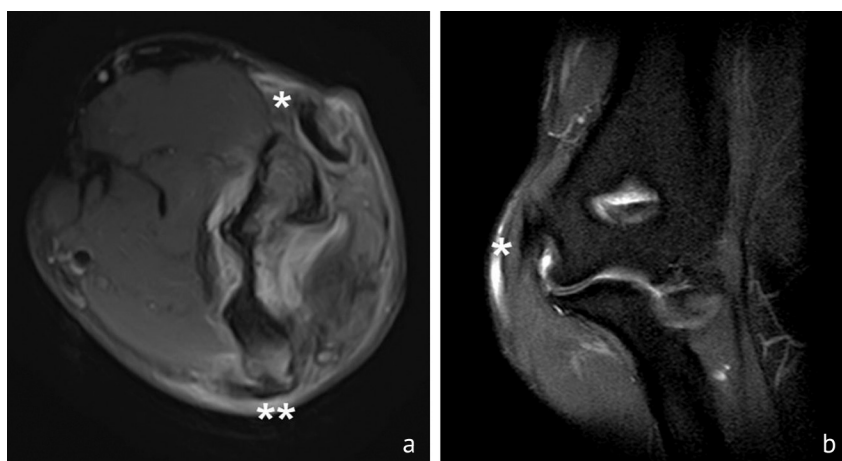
Scans of the area of interest: post-traumatic instability of the elbow joint of the left upper limb in coronal (a) and sagittal (b) sections of T1-weighted MRI with measurement of the MUCL (*) and LCLC () the structures
